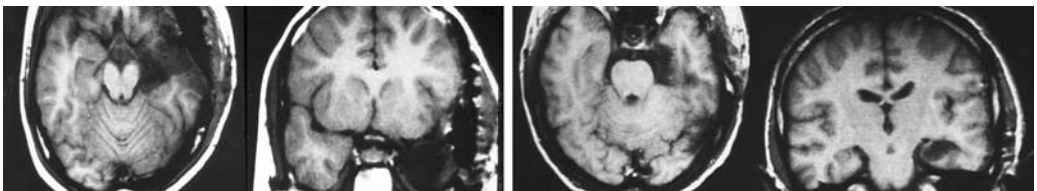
MRI scans showing a right corticoamygdalohippocampectomy (left two images: horizontal slice at left, coronal right) and a right selective amygdalohippocampectomy (right two images: horizontal slice at left, coronal right).
